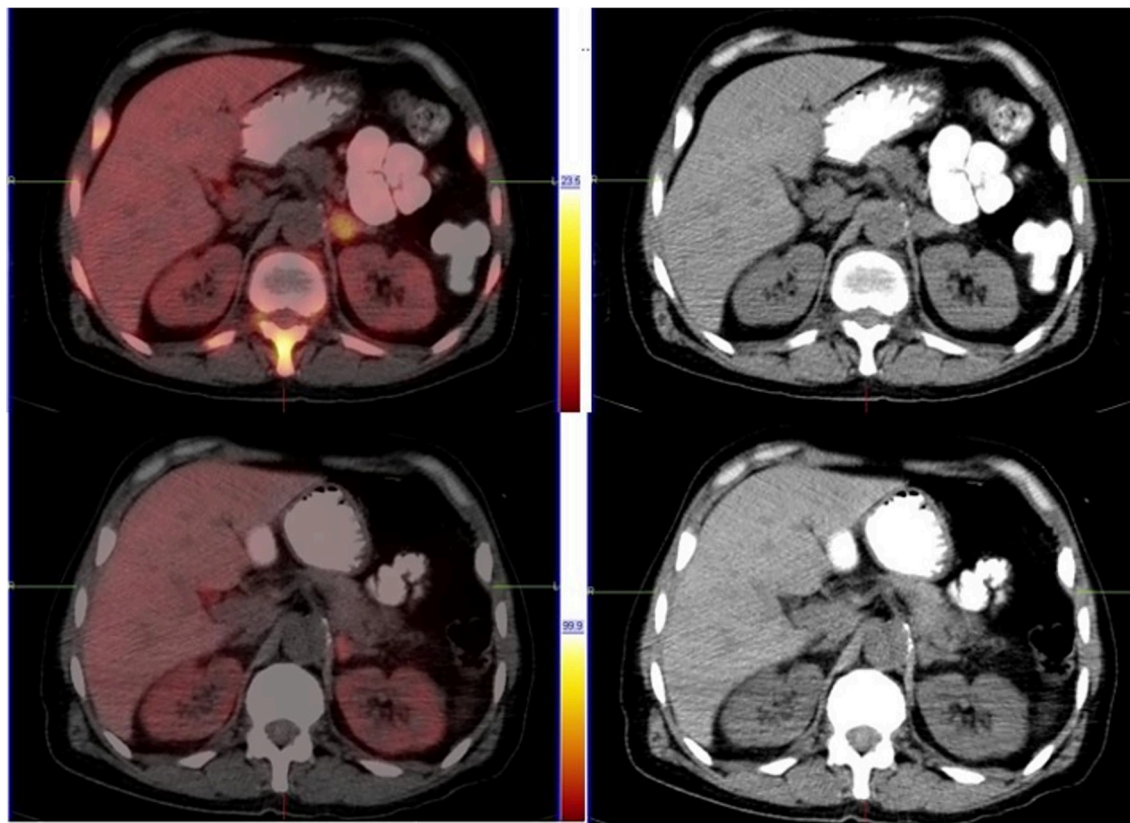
Fluorine 18 (^{18}F) positron emission tomography/computed tomography (PET/CT) and CT only images of a 58-year-old African male with high-risk adenocarcinoma [Gleason score 5+4 and prostate-specific antigen (PSA) 4, 441 ug/L] referred to our facility for radioligand therapy workup. The images in the top row reveal increased prostate-specific membrane antigen (PSMA) expression in the medial limb of the left adrenal gland [standardized uptake value (SUV): 15.04], which is confirmed to be bulky on the CT-only images. The images below are post 4 cycles of ^{177}Lu -PSMA radioligand therapy images, revealing a reduction in PSMA expression (SUV: 5.30) and the size of the previously affected adrenal gland, confirming the response to therapy. The adrenal gland is one of the atypical sites for metastatic prostate cancer (1). In a retrospective study involving 620 patients with biopsy-proven prostate cancer, adrenal metastases were observed in 12 of the 82 patients (15%) with an atypical site of metastatic disease (2). However, adrenal metastases are considered extremely rare, accounting for 1% of all metastatic cases (3).
